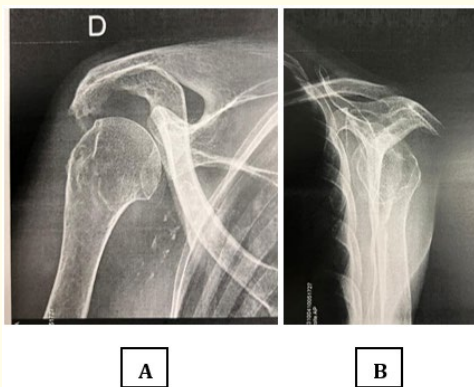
X-rays after reduction of posterior shoulder dislocation.
